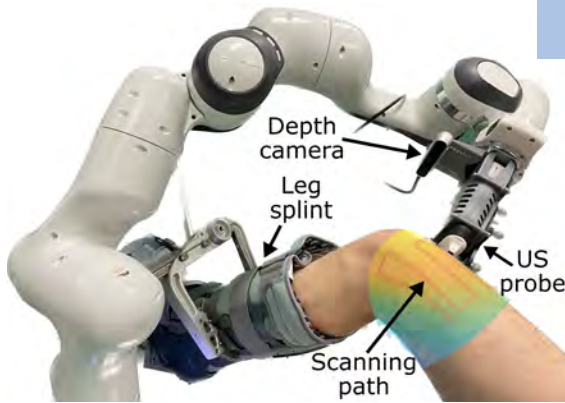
Setup for autonomous robotic ultrasound scan of the knee
